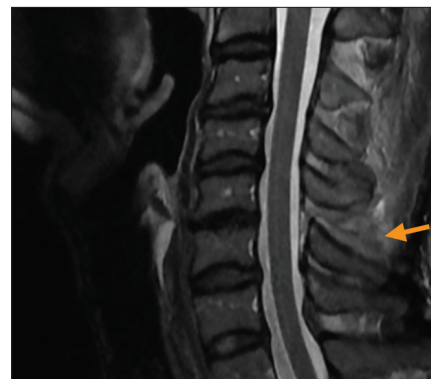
Sagittal, T2-weighted magnetic resonance image demonstrating complete disruption of the interspinous and supraspinous ligaments at C5-6.
